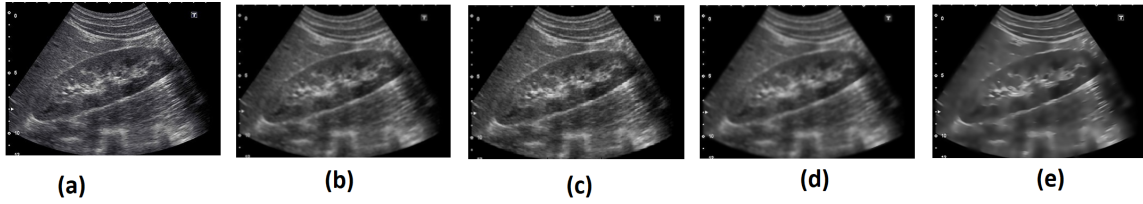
(a) Kidney ultrasound image. De-speckling performance of (b) Frost, (c) Lee, (d) SRAD, (e) Proposed method.
